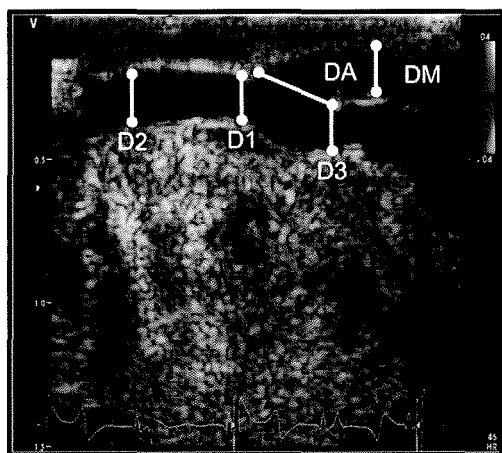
Two-dimensional (B-mode) ultrasound image of the LIMA-LAD anastomosis in longitudinal view. D1: diameter of the LAD at the toe of the anastomosis. D2: diameter of the LAD 5–10 mm distal to the toe of the anastomosis. D3: diameter of the LAD at the heel of the anastomosis. DA: length of the anastomosis proper. DM: diameter of the left mammary artery graft.
